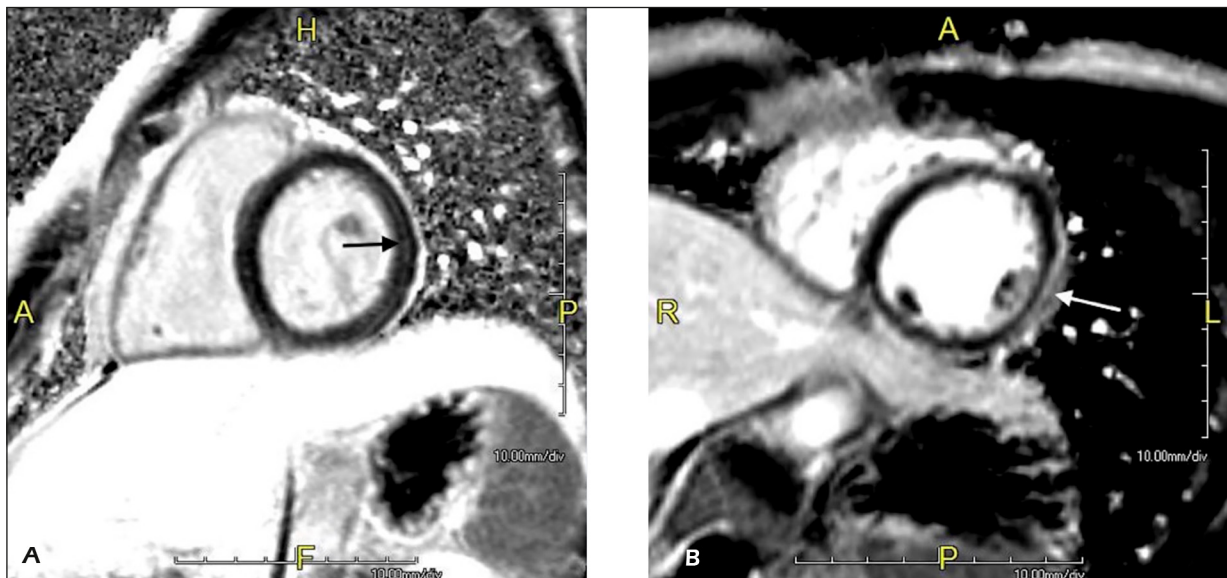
Cardiac magnetic resonance images showing mid-myocardial (A), and sub-epicardial localization of LGE in two different patients (B).
